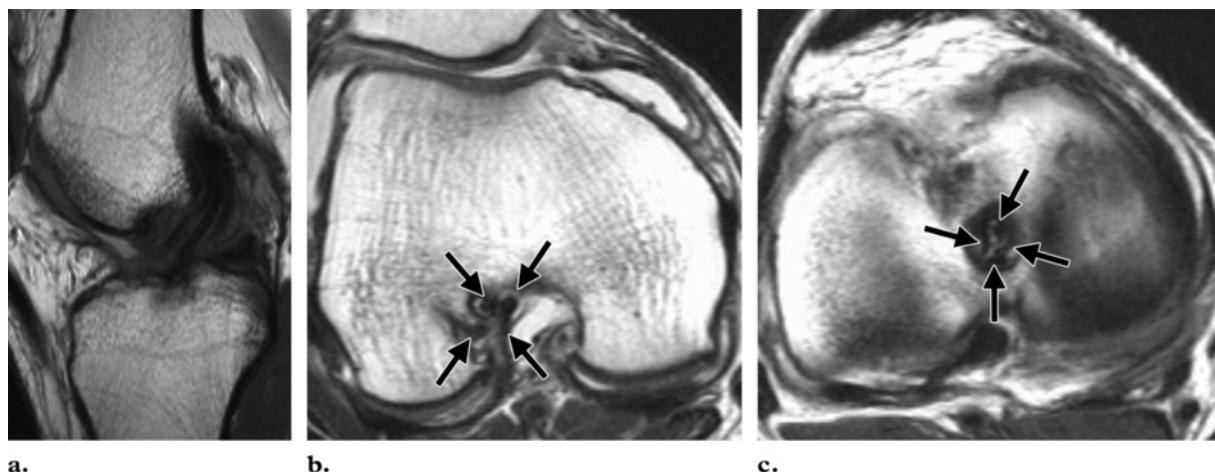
Four-strand hamstring graft. (a) Sagittal proton-density–weighted fast spin-echo MR image shows linear regions of intermediate signal intensity between the strands of a hamstring graft. (b, c) Axial proton-density–weighted MR images at the level of the openings of the femoral (b) and tibial (c) tunnels show the four strands (arrows) of a single-bundle, double-looped hamstring graft.
